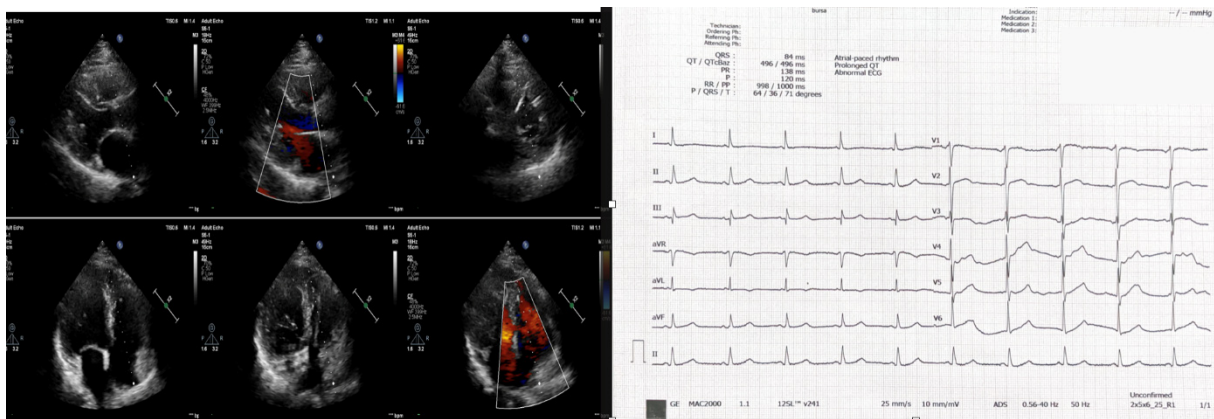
Transthoracic echocardiography performed at 1-month follow-up after hospital discharge.
